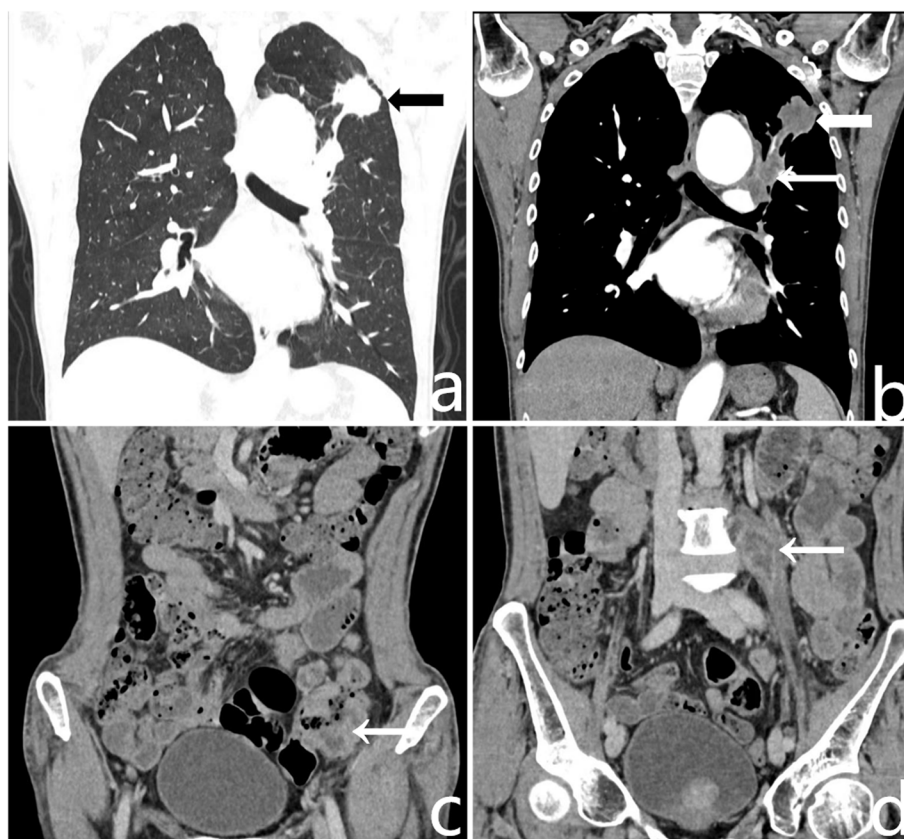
CT images of a 59-year-old male with SMARCA4-dNSCLC at the time of initial diagnosis. a The coronal lung window image shows a mass measuring 3.8 cm × 3.1 cm in the posterior apical segment of the upper lobe of the left lung, accompanied by lobulation and spiculation signs (black arrow). b The coronal mediastinal window image shows that the mass had mild heterogeneous enhancement (white thick arrow) and was accompanied by enlarged lymph nodes in the left hilar region (white thin arrow); c The coronal CT of the abdomen shows uneven thickening of the sigmoid colon wall (white arrow), d and an enlarged lymph node in front of the left psoas major muscle is observed (white arrow)
